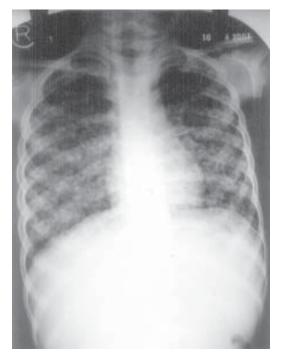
X-ray chest on admission suggestive of bilateral miliary shadows.
